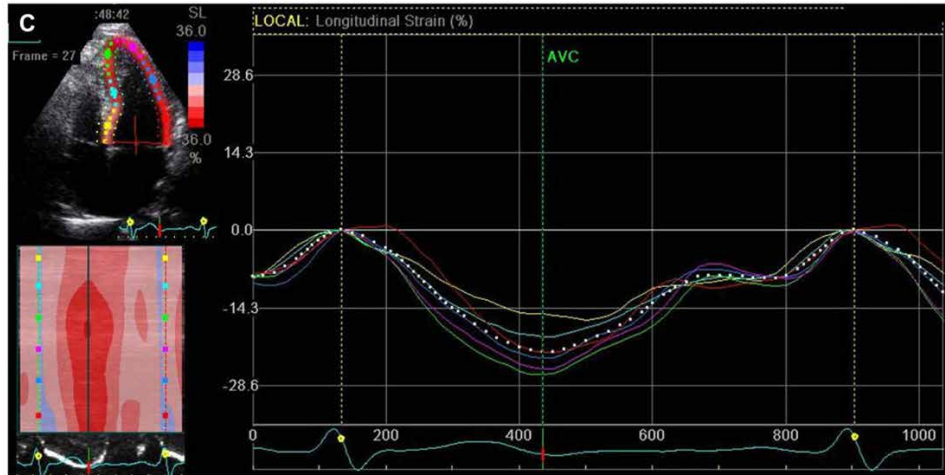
Effect of sliding pericardium in myocardial dynamics. Longitudinal strain measurements captured using speckle tracking echocardiography for a healthy heartbeat. Image taken from [19].
